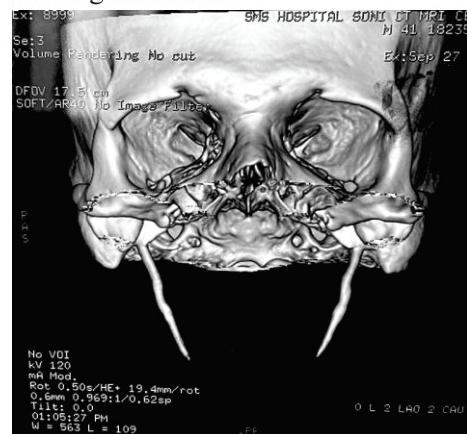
3D CT scan showing bilateral elongated styloid process
